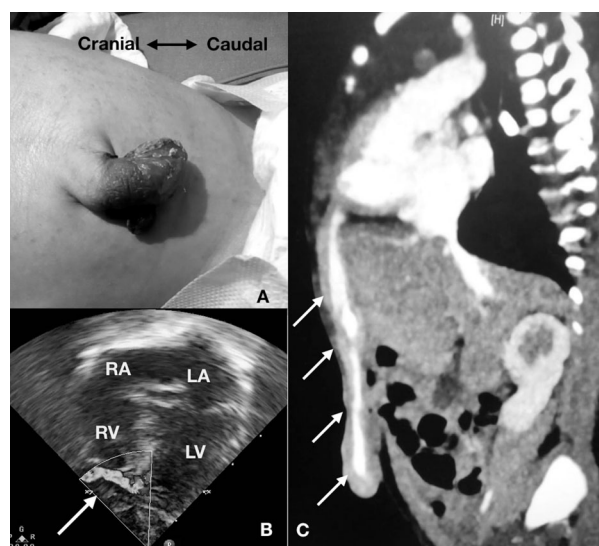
(a) Clinical photograph of umbilical swelling; (b) echocardiogram in four chamber view showing a vascular channel (white arrow) arising from left ventricle apex; (c) CT angiographic section in sagittal view showing the abnormal vascular channel (white arrows) arising from left ventricle apex.
